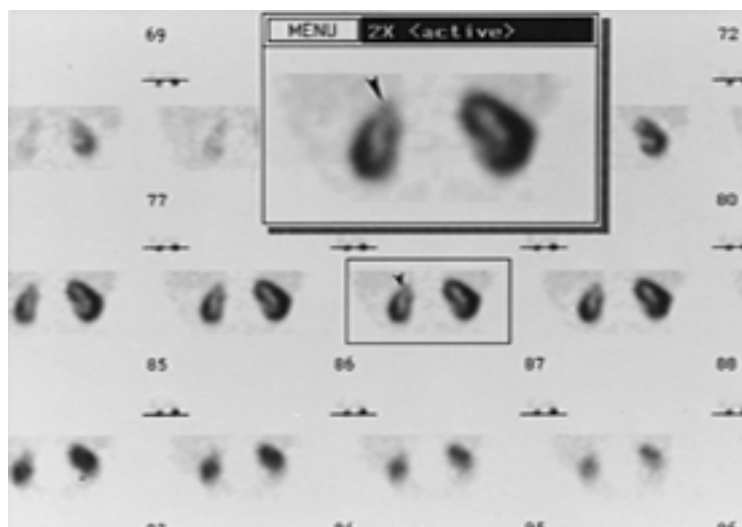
17. Boy, 8 years old, with chronic renal insufficiency and recurrent urinary tract infections. ^{99m}Tc DMSA coronal SPECT images show the right kidney to be smaller than the left kidney with a significant scar in the upper pole (*arrowheads*). The selected image is magnified. This size defect is often difficult to demonstrate on planar views.
